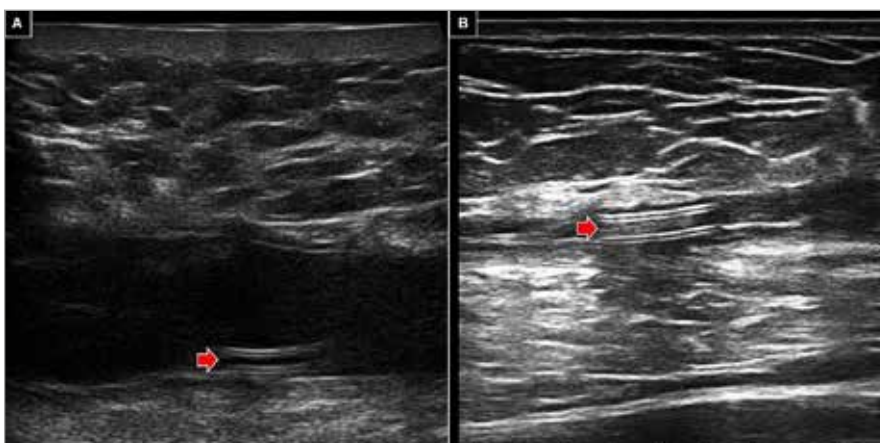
Ultrasound-guided puncture and drainage of the collection with a catheter (red arrow) with subsequent instillation of talc.
